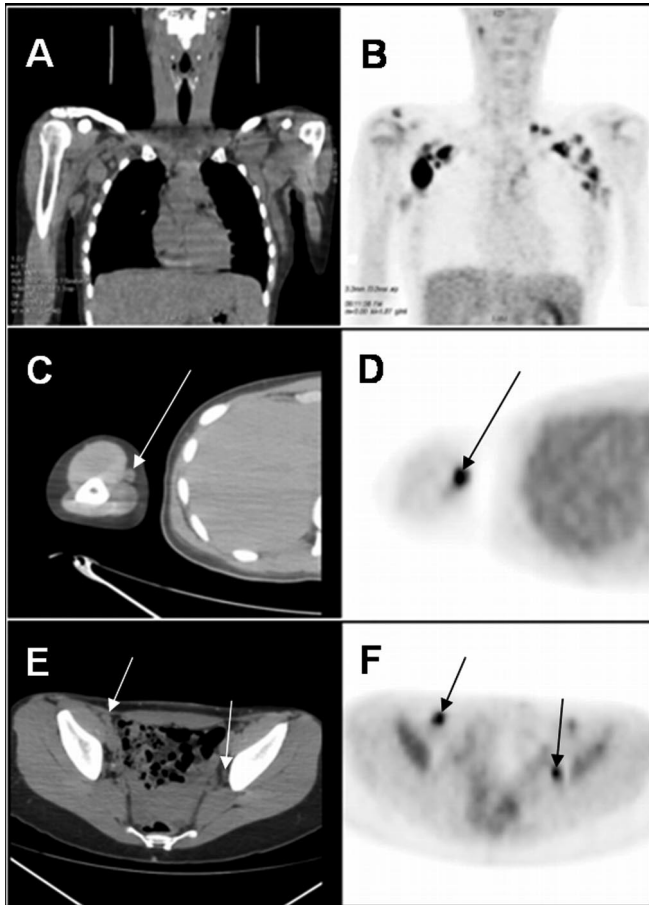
Restaging F-18 fluoro-2-deoxyglucose positron emission tomography/computed tomography (F-18 FDG PET/CT) study of a 28-year-old woman with a history of papillary thyroid carcinoma. She presented with weight loss and palpable nodes in the neck and supraclavicular regions for 6 months. Total thyroidectomy and radioiodine ablation (3.7 GBq) were performed 9 years ago. Recent I-131 whole-body scan was negative and serum thyroglobulin levels were undetectable. She complained of hands and wrists symmetrical polyarthralgia and morning stiffness for 2 years. Laboratory tests revealed high inflammatory markers, positive rheumatoid factor, and high levels of anticyclic citrullinated peptide antibodies, which confirmed the rheumatoid arthritis hypothesis.^{1–3} Coronal and axial views on PET/CT show markedly increased F-18 FDG uptake in cervical, supraclavicular, and axillary lymph nodes (panels A and B); right arm subcutaneous node (panels C and D); and pelvic lymph nodes (panels E and F). Based on clinical criteria and image findings,^{4,5} a second malignancy hypothesis became the most likely. However, the right axillary lymph node biopsy revealed benign lymphoid hyperplasia. After treatment with leflunomide, aceclofenac, and deflazacort, the patient showed marked clinical improvement with pain relief and palpable node volume reduction.
